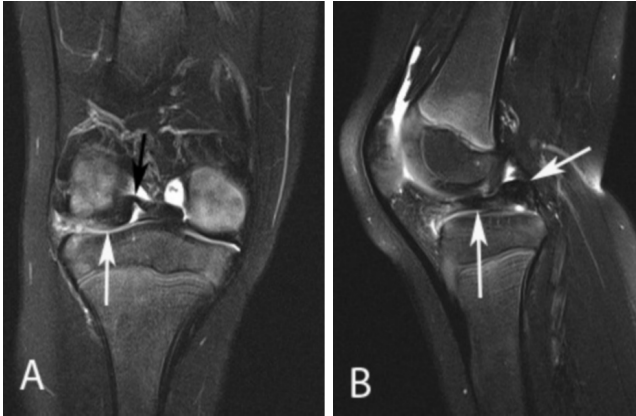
Discoid lateral meniscus in a toddler. (A) Coronal, T2-weighted, fat-suppressed MR image of the right knee posteriorly demonstrates a homogeneous hypointensity (white arrow) extending across the entire lateral joint space, indicative of a discoid meniscus. There is hyperintensity in the meniscal body with an oblong focus in the intercondylar notch (black arrow) representing a torn meniscus with a flipped anterior horn posteromedially. (B) Sagittal, T2-weighted, fat-suppressed MR image of the middle right knee (at slice thickness of 3 mm with slice spacing of 3.3 mm) demonstrates a homogeneous area of low signal intensity extending anteriorly to posteriorly (vertical arrow) with thickened posterior meniscal tissue (angled arrow) and absence of the anterior portion of the discoid meniscus, resulting in loss of the normal "bow-tie" configuration.
